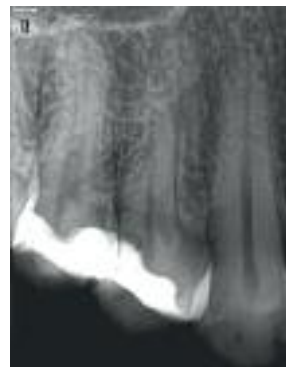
Preoperative radiograph showing recurrent caries below existing amalgam restorations in teeth # 14 and 15
